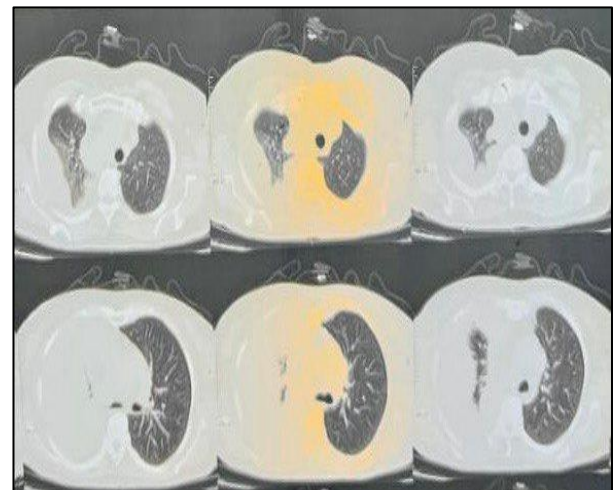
CT thorax suggestive of right sided effusion.
